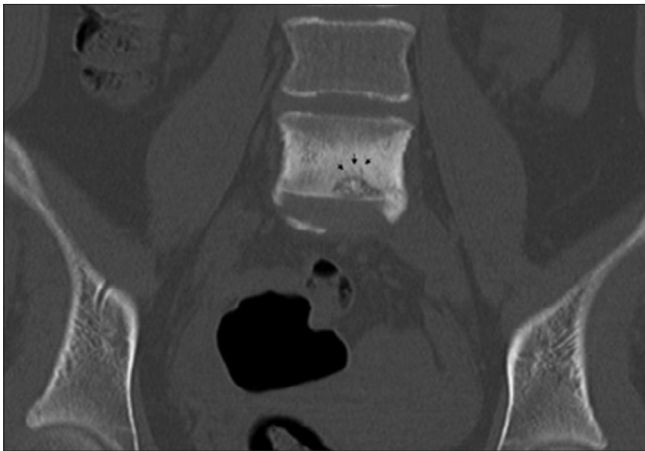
Computed tomography scan coronal image of the L5 vertebral body showing (with black arrow head) multiple grooves in the lower part of vertebral body
